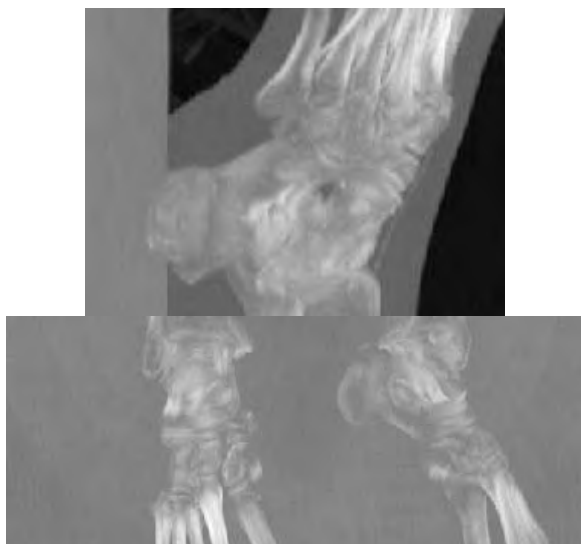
MIP Results of Foot CTA Images
